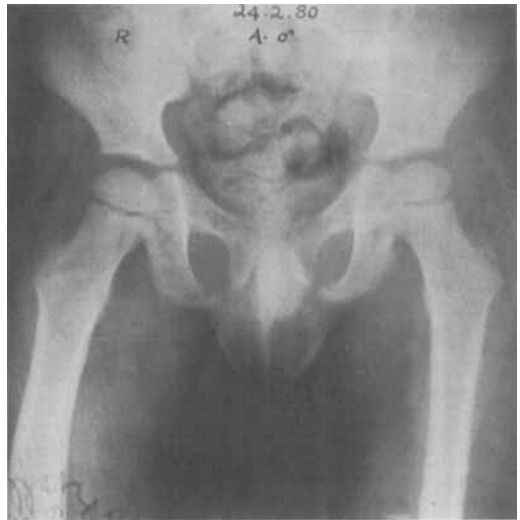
X-rays showing the varus angulation migrating peripherally.
